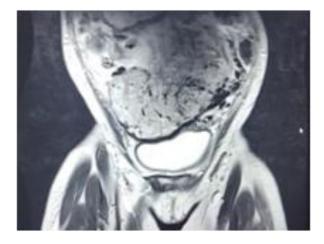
MRI showing placenta and fetus in the abdominal cavity
